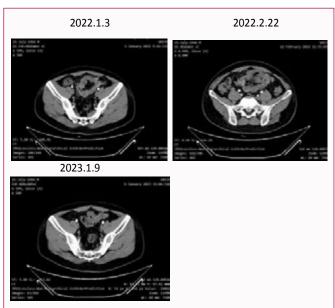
CT imaging of the patient during treatment. The tumor appeared enlarged and the disease progressed after chemotherapy, but after treatment with immune-combination chemotherapy the results showed that the tumor was significantly smaller.
